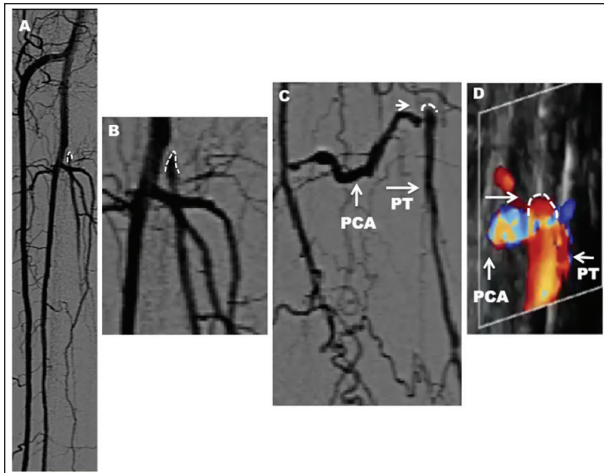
This figure explores angiographic and ultrasound generated CTO cap analysis and iodinated contrast imaging of the tibial vessels. Notice the retrograde concave morphology of the proximal CTO cap in the PT (white dotted line) (A). Amplified image shows the retrograde concave morphology of the proximal cap in the PT (B). Amplified image shows the distal reconstitution of the PT at the level of the ankle via the posterior communicating artery (PCA) (C). Notice the retrograde concave cap of the PT and corresponding reconstitution of the distal PT via the PCA, as seen with EVUS (D).
